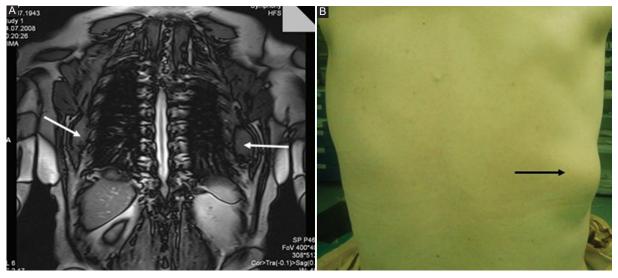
A: T1-weighted coronal magnetic resonance image of ED in a case with bilateral involvement (white arrows). B: view of ED in the lower corner of the scapula (clearly visual with anterior flexion of arm black arrow).
